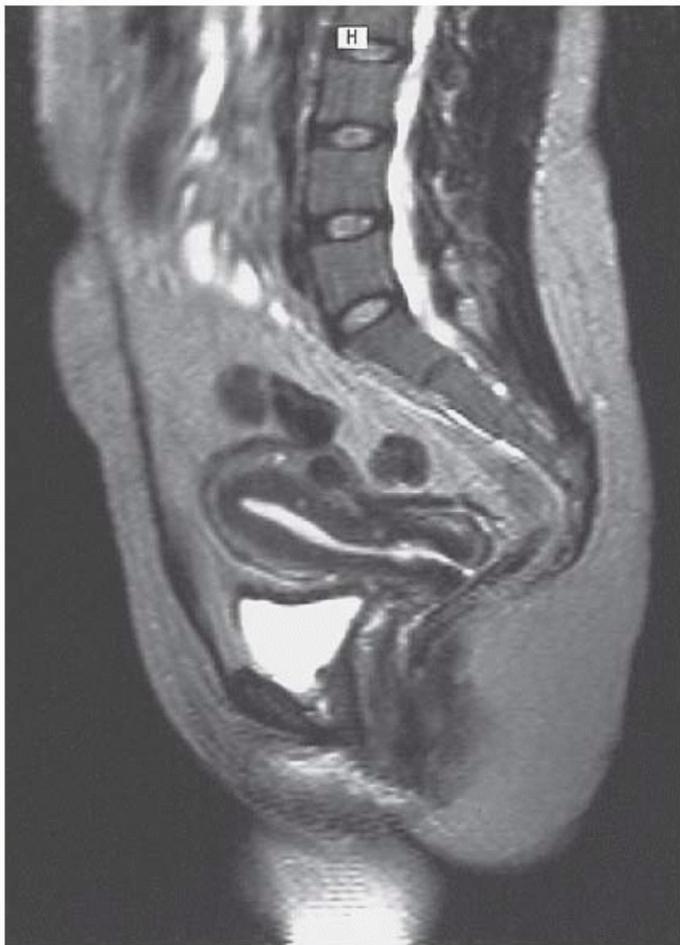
A: The ultrasound evaluation of this patient with a very large leiomyoma was not helpful in delineating the leiomyoma from the adnexa. B: The MRI study demonstrated multiple leiomyomas distinctly separate from the adnexa bilaterally. The ovaries are seen bilaterally with multiple cysts. (Image courtesy of Deborah Baumgarten, MD.)
